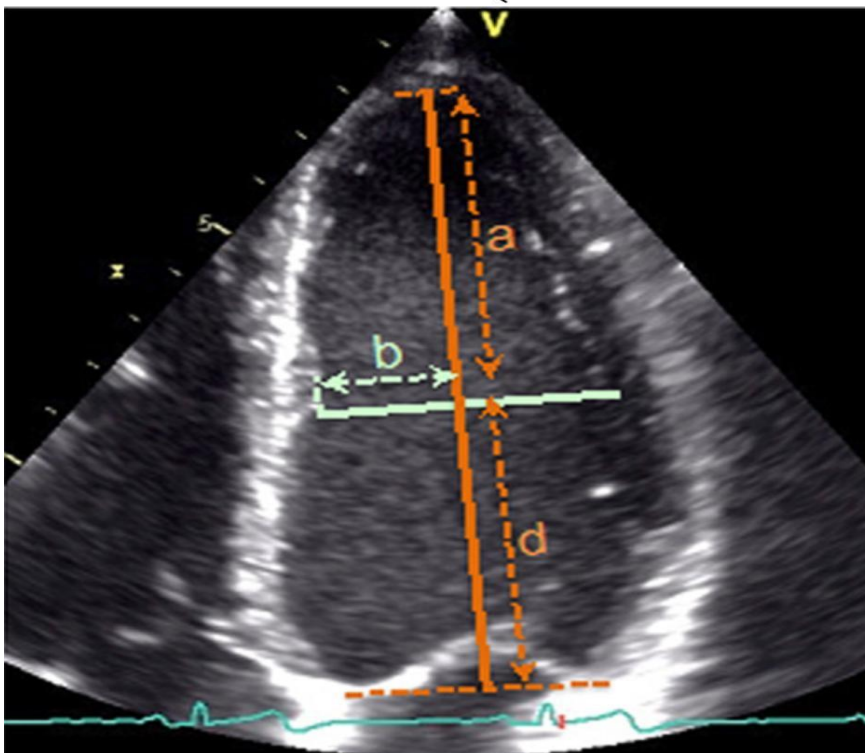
Measurement of LV dimensions in 2-D Echocardiography for truncated ellipsoid formula [Source: Lang et al ²⁴]
